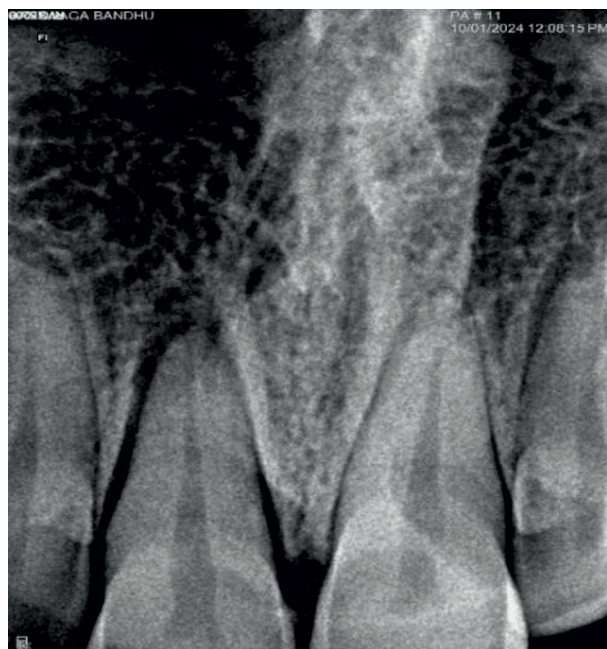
RVG radiograph showing dislodgement of tooth from the socket
